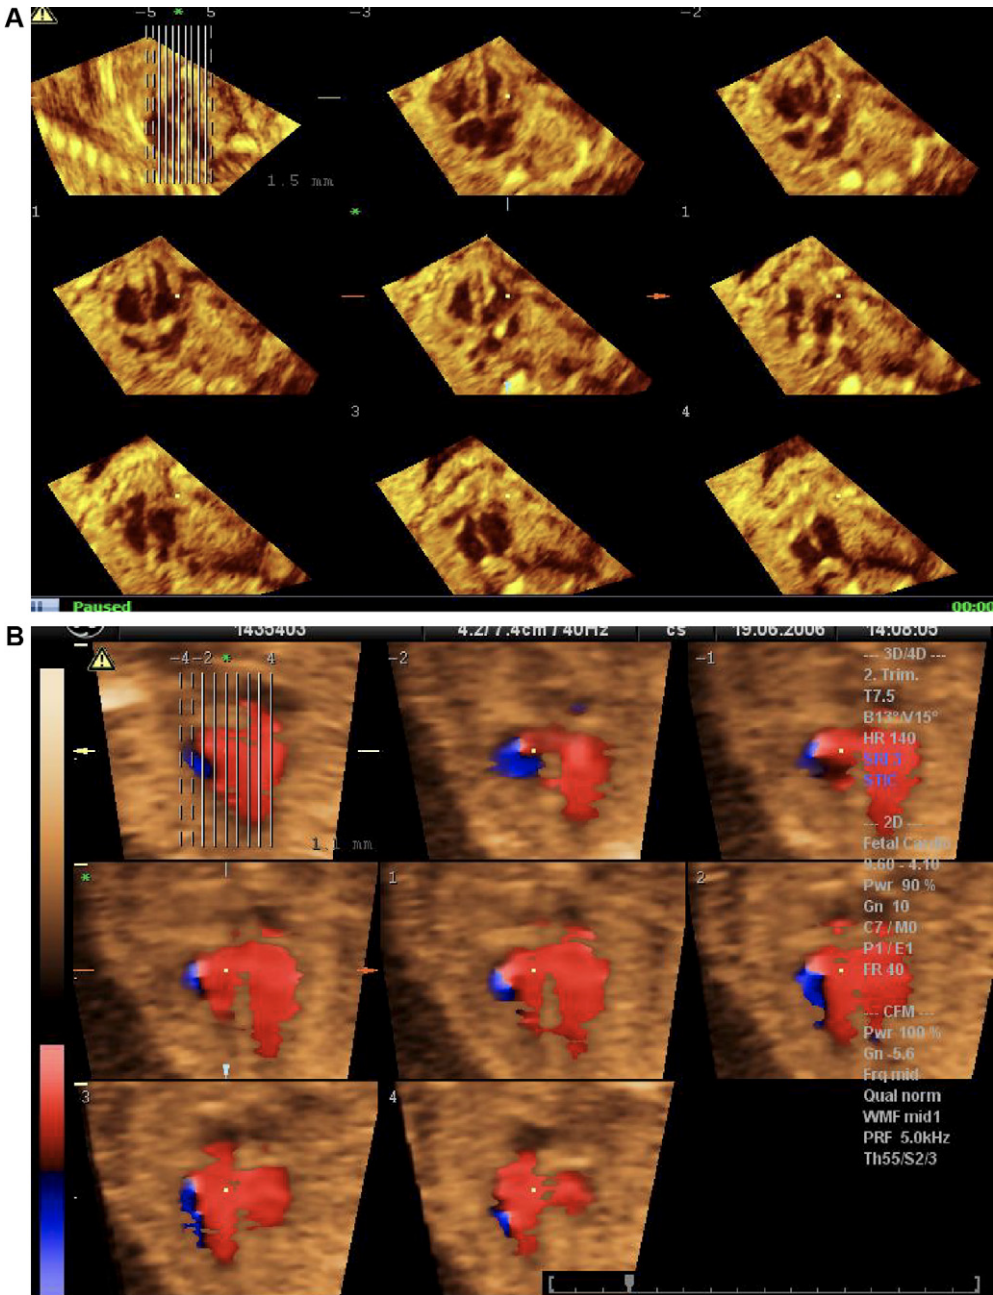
Tomographic imaging through parallel planes neighboring the four-chamber view of (A) a normal fetal heart and (B) biventricular inflow with color Doppler.
